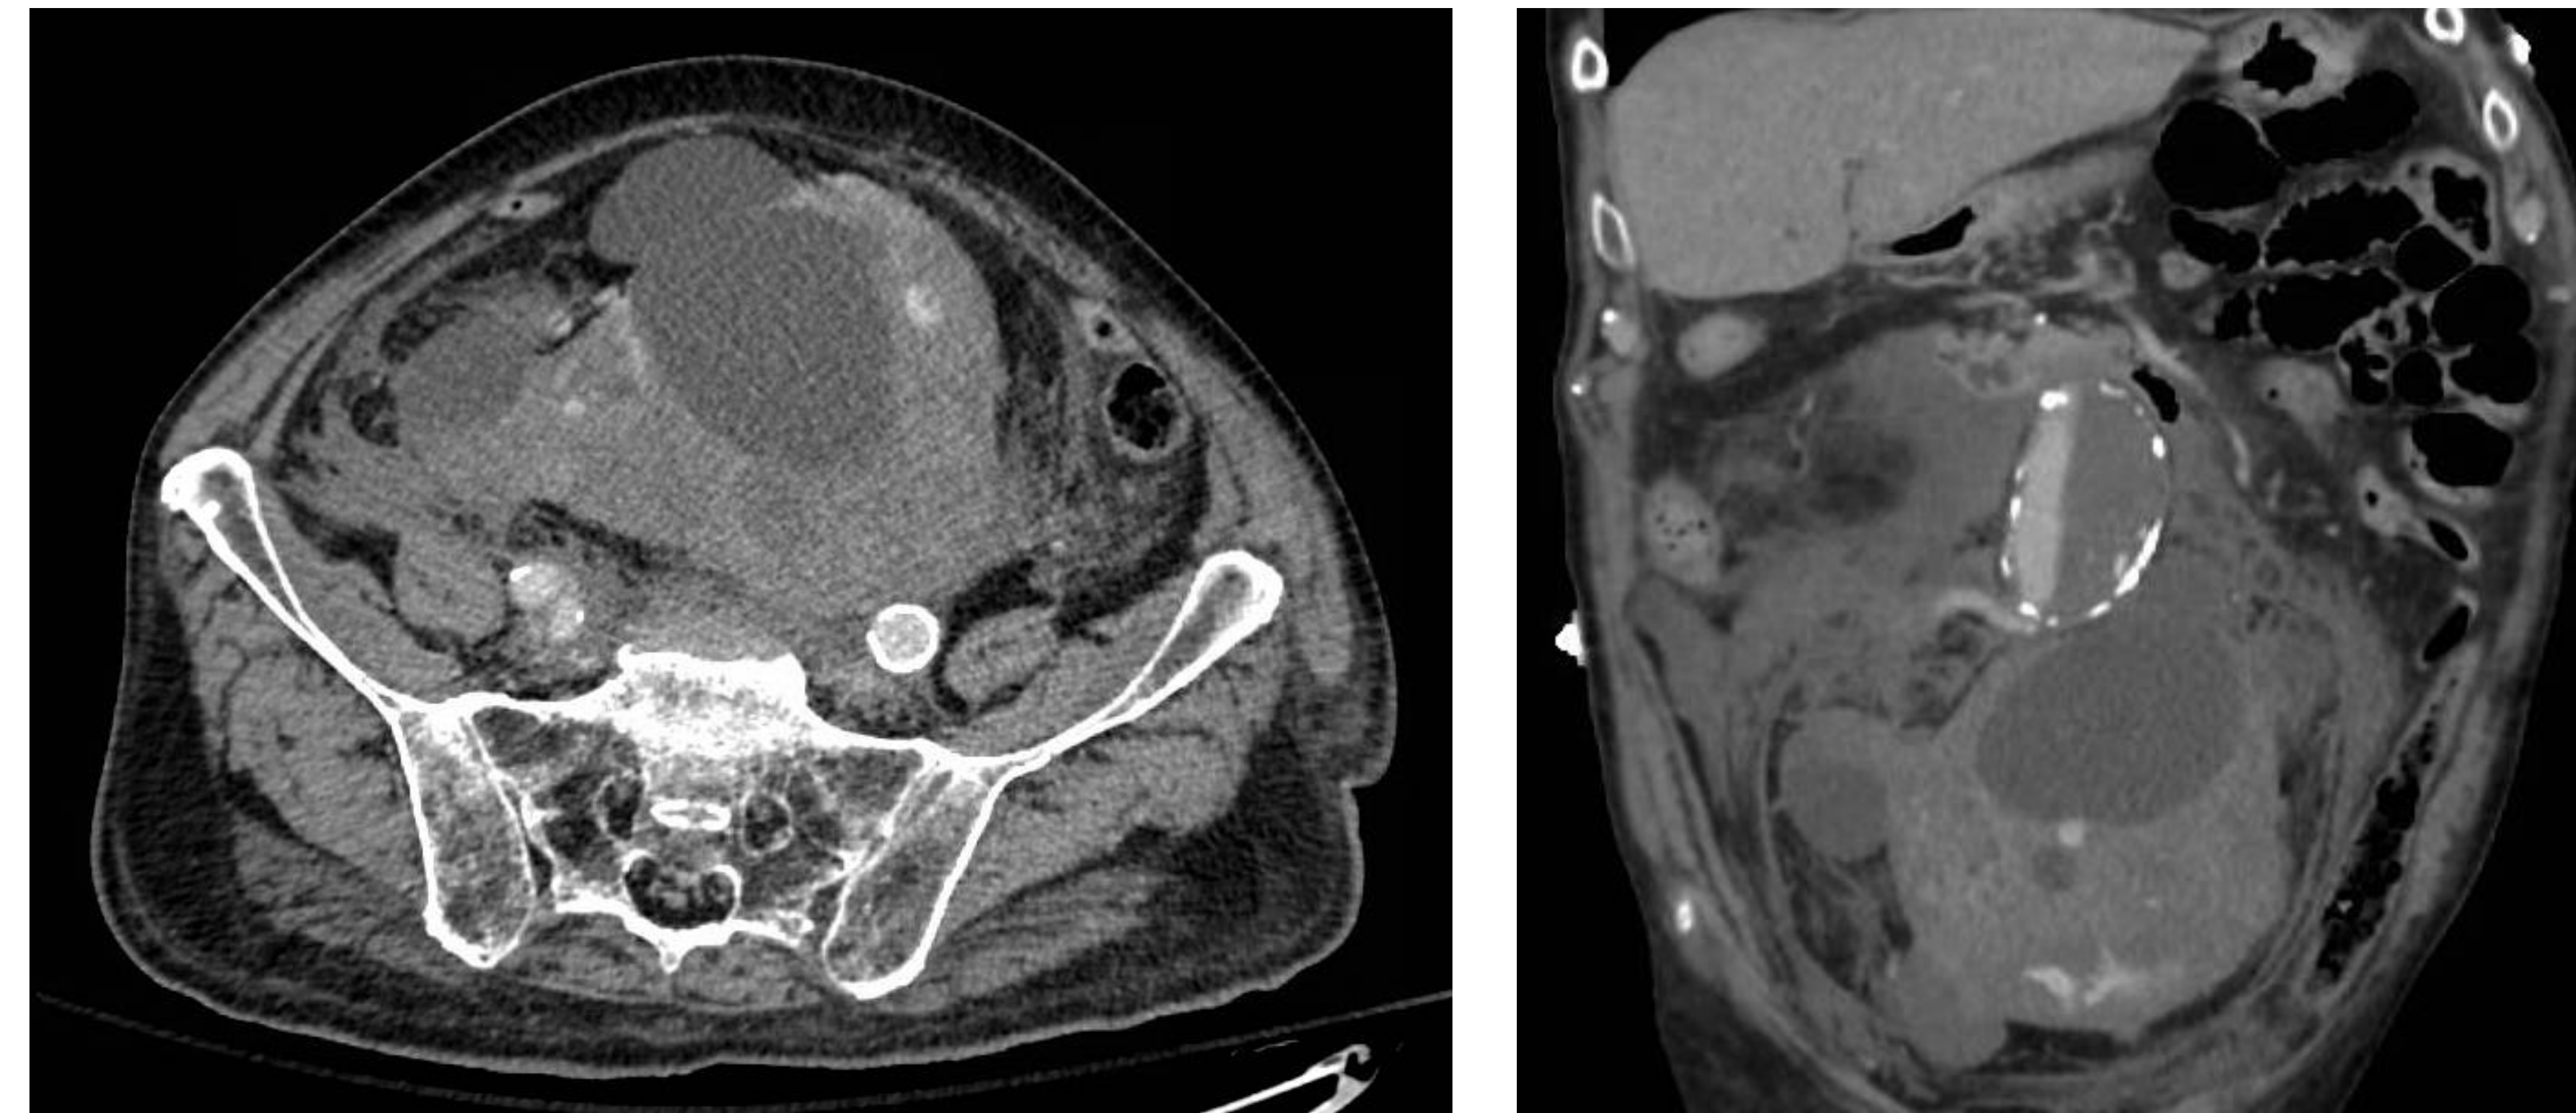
Axial (left) and sagittal (right) CT images obtained in the arterial phase of contrast demonstrate enlarged right pelvic kidney with multiple cysts with active extravasation of contrast within the inferior aspect of the mass.
